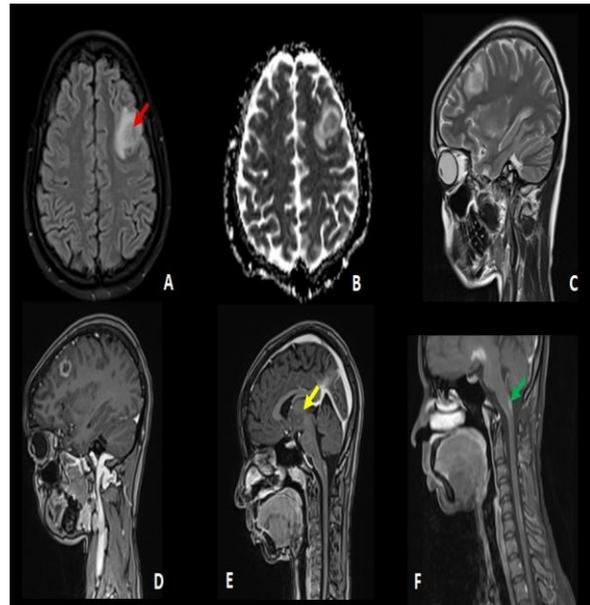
Tuberculoma with tuberculous meningitis :Axial FLAIR (A), ADC (B) and sagittal T2 (C), T1 after gadolinium injection (D, E, F): left frontal lesion (red arrow) rounded in central T2 hyposignal surrounded by a peripheral T2 hypersignal taking contrast in the periphery in an annular fashion. There is a second lesion of the same type at the base of the cerebral peduncle (yellow arrow) and meningeal contrast opposite the gracile fasciculus (green arrow).
